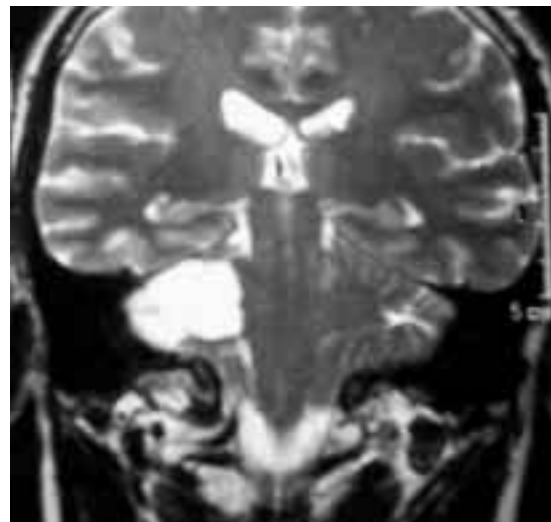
Coronal MRI: large epidermoid cyst in CPA.
